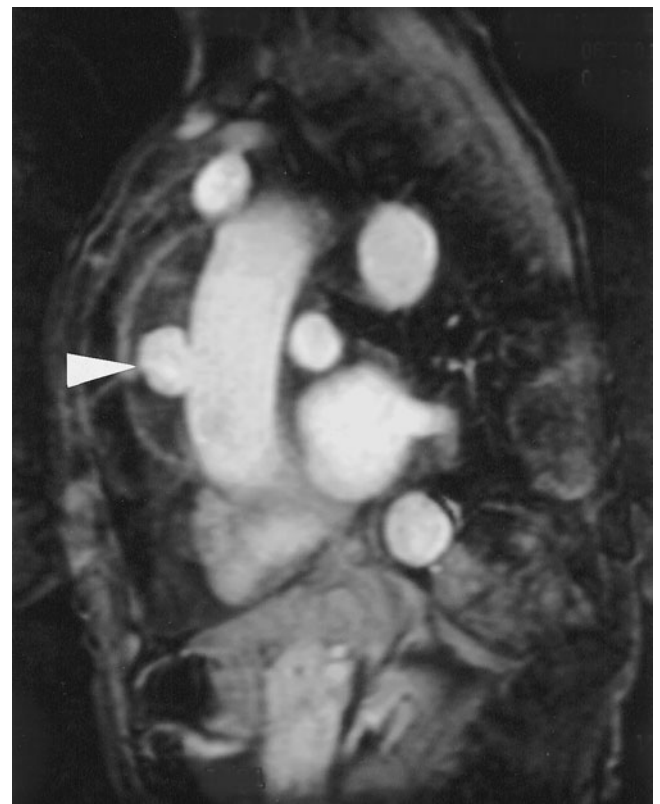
Sagittal contrast-enhanced MRI of penetrating atherosclerotic ulcer of the ascending aorta (arrowhead).
